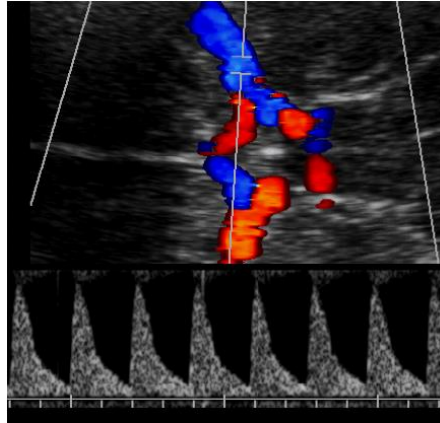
Insonation and obtention of the flow velocity wave of the middle cerebral artery. Observe the zoom, the insonation angle closer to 0° in the most proximal site next to the Willis polygon and the adjustment of the velocity scale aiming for the wave to fill 75% of the Doppler screen
